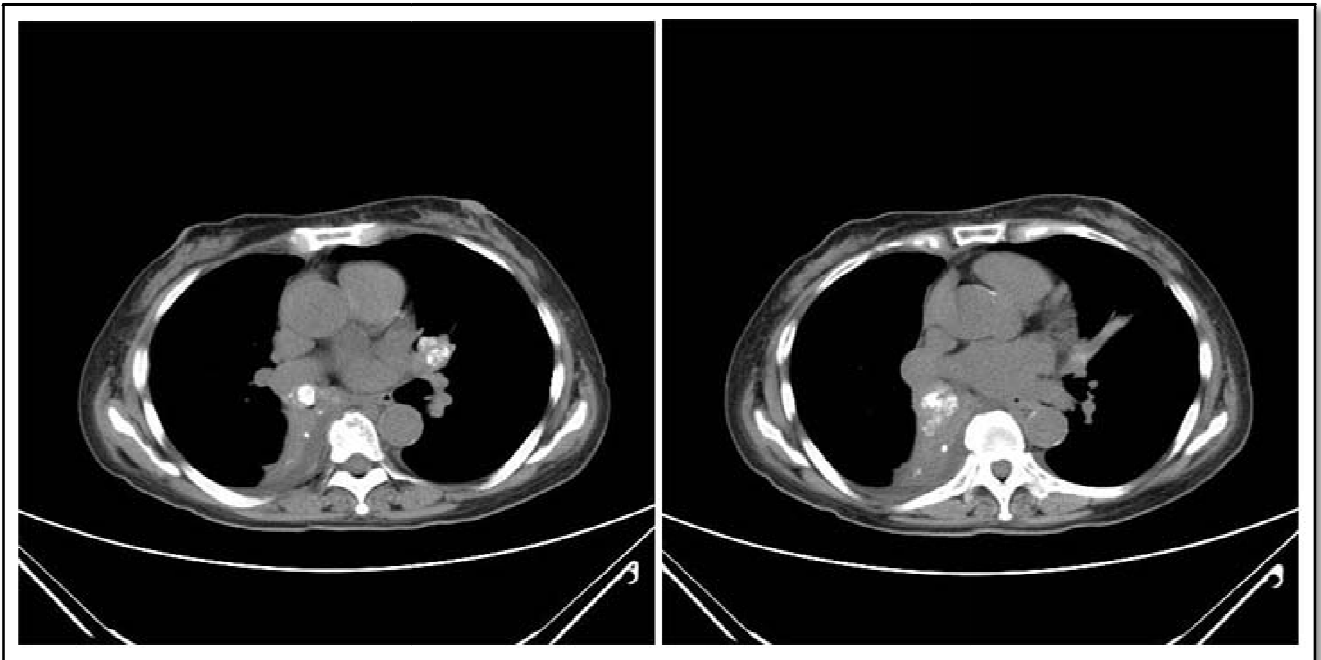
(b)Unenhanced CT of the chest performed 10 days earlier demonstrated metastatic lymphadenopathy and enlarged calcified lymph nodes at the bilateral hilar regions.
